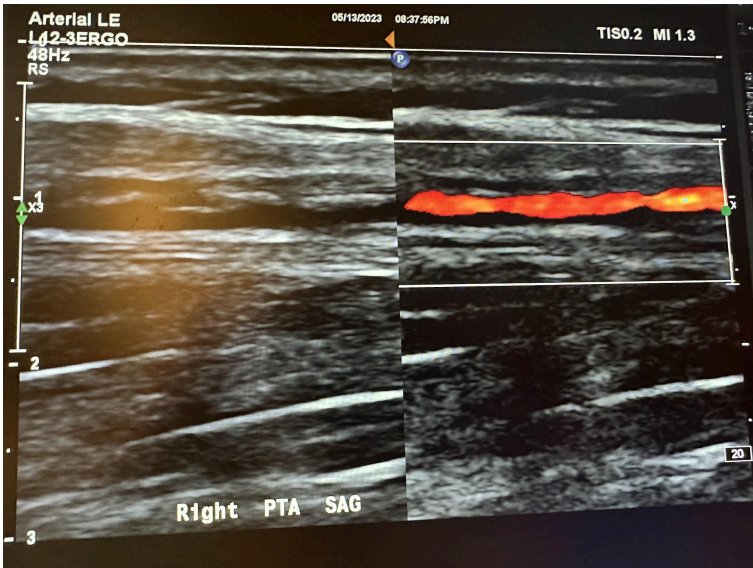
Side-by-side sagittal images of the right posterior tibial artery without color Doppler and with color Doppler.
